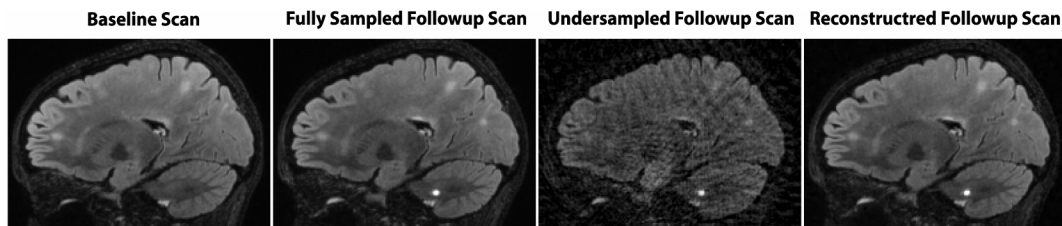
Reconstruction of undersampled T2 FLAIR (CUBE) images from accelerated (undersampled) data using proposed baseline scan regularized reconstruction (single coil channel, undersampling factor $R=8$).
